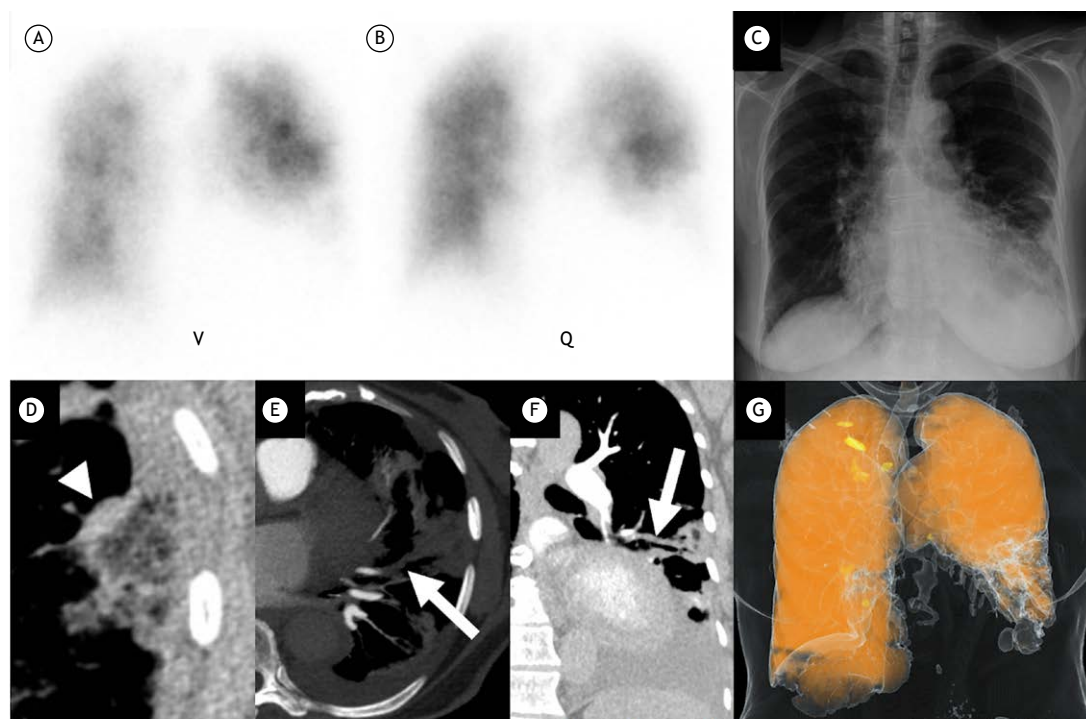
Planar ventilation/perfusion (V/Q) scintigraphy (anterior view, in A and B) and chest X-ray (frontal view, in C) reveal a triple-matched defect in the left lower lobe. An axial CT image (in D) shows a reversed halo sign (RHS) with low-attenuation areas within the halo (reticular RHS; arrowhead) in a juxtapleural location, a finding suggestive of pulmonary infarction. On CT angiography, an axial maximum intensity projection image (in E) and an oblique coronal image (in F) show a complete filling defect in the subsegmental arterial branch (arrow) supplying the opacified area in the left lower lobe. A color-coded pulmonary blood volume map from dual-energy pulmonary CT angiography (in G) shows an iodine defect in the left lower lobe.
